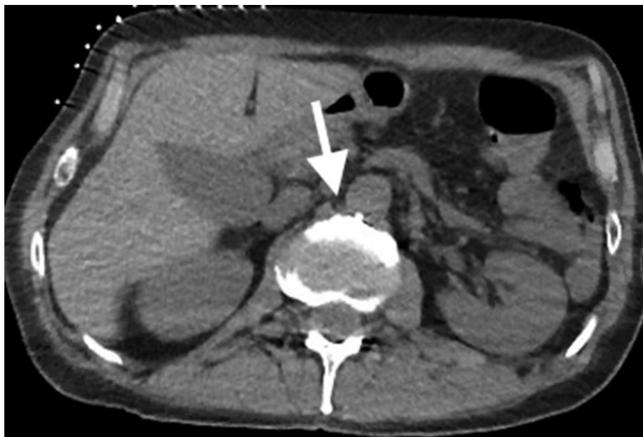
Diagnostic angiography/computed tomography performed prior to needle insertion to visualize the cisterna chyli (arrow)
